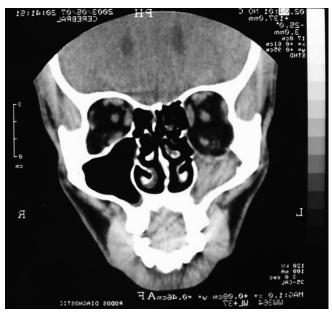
Preoperative CT. Opacity of the left maxillary antrum. Note the concurrent disruption of the orbital floor and the prolapse of the content of the orbit into the antrum.
